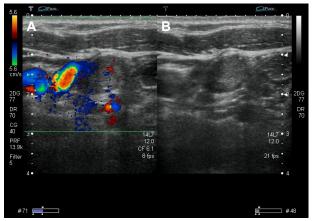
Ultrasonography before and after radiofrequency ablation therapy. The left image (A) shows high intranodular vascularity before the treatment, while the right image (B) shows much less vascularity in the lymph node.
